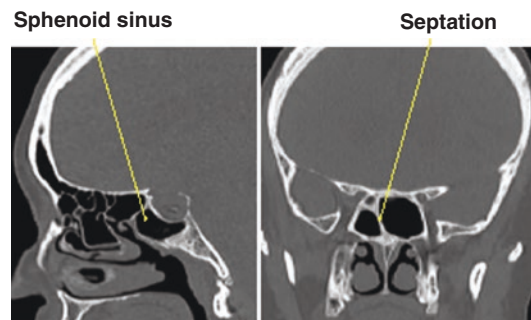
Pre-operative CT showing sellar pneumatization of the sphenoid air sinus (left) and a single sphenoid septum (right)
